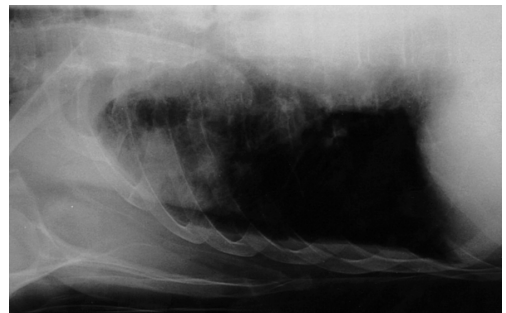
Lateral expiratory decubitus radiograph, clearly showing a horizontal fluid layer of approximately the same thickness in a 52-year-old male patient with obstructive pneumonia of the right upper lobe due to lung cancer.
